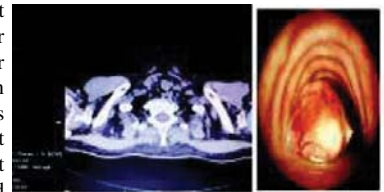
(a) CT thorax showing an intra-tracheal lesion; (b) Bronchoscopic image showing the intra-tracheal lesion.
